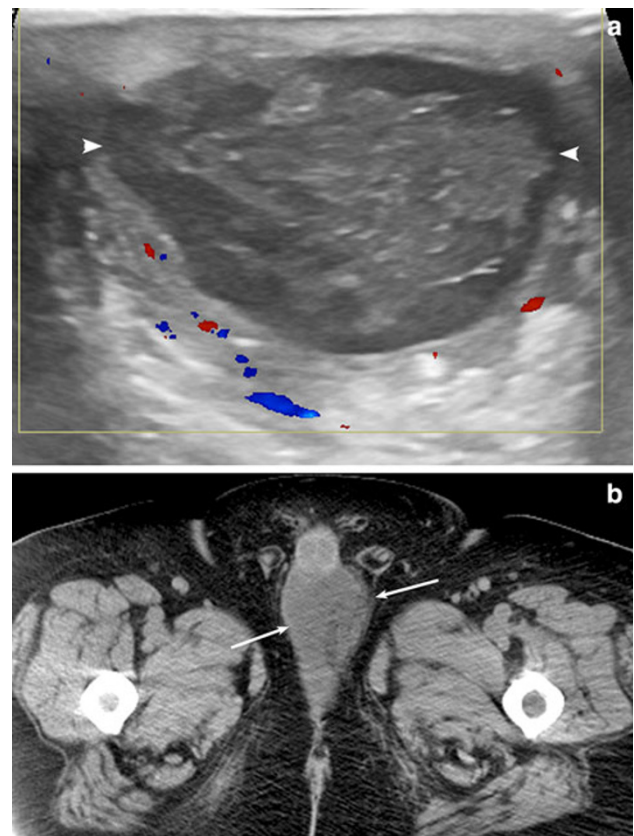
Perineal abscess presenting as scrotal pain. a Transverse color Doppler US image in a 33-year-old patient with scrotal pain and history of suppurativa hidradenitis shows an encapsulated heterogeneous fluid collection (arrowheads) in the perineum. b Corresponding CT image (same patient as in part a) shows the low attenuation fluid collection posterior to the base of the penis. The patient was treated with incision and drainage. Cultures were consistent with a polymicrobial infection, mostly due to *Staphylococcus aureus*
